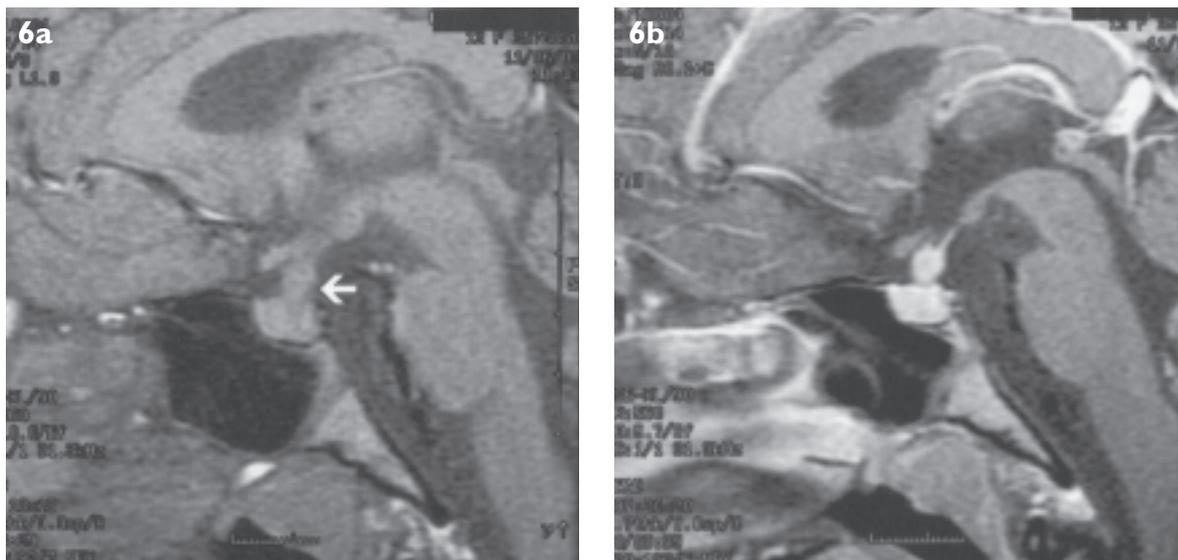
MR images of child with Langerhans cell histiocytosis. (a) Unenhanced sagittal T1-weighted image shows thickening of pituitary stalk (arrow) and absence of posterior pituitary bright spot. (b) Enhanced sagittal T1-weighted image shows intense enhancement of thickened pituitary stalk.
